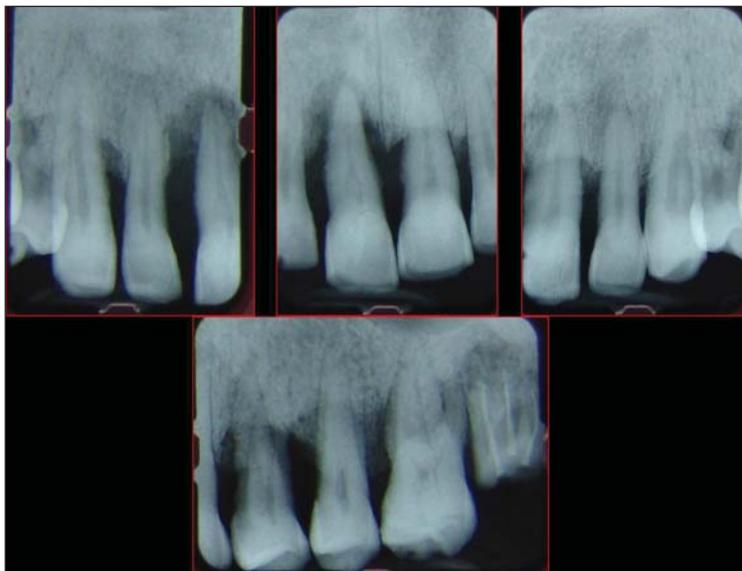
X-ray image at presentation
